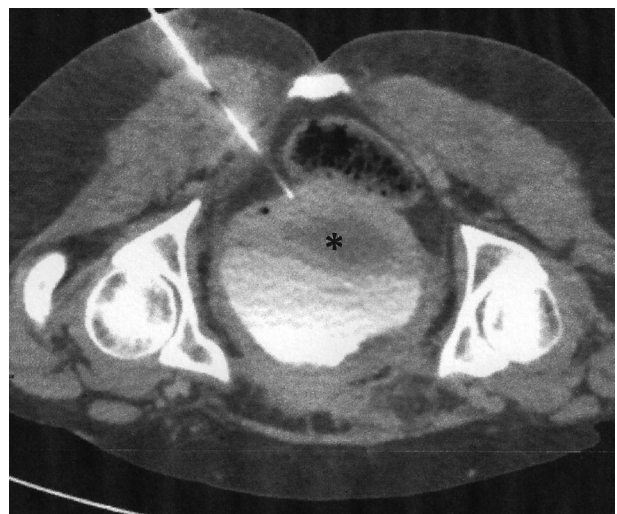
CT scan obtained during imaging guided abscess drainage showed the needle placed into the abscess (*), avoiding damage of the rectum and major pelvic neuro-vascular structures.
